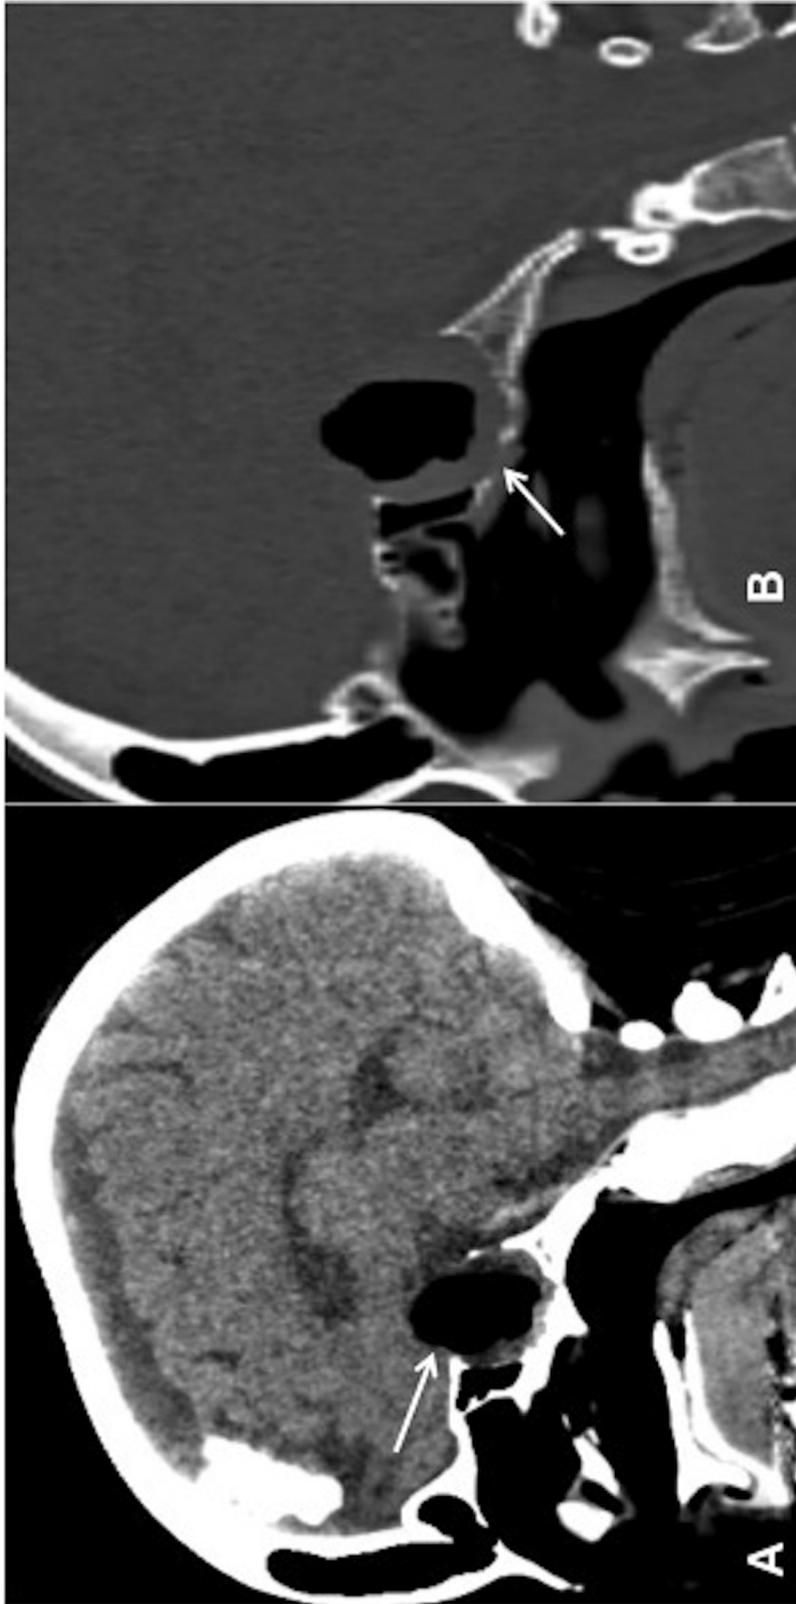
Midline sagittal non-contrast CT image of the head in soft tissue window (A) and slightly off-midline sagittal image in bone window (B) demonstrate marked expansion of the sella, and a large central collection of air/gas within the sella and suprasellar cistern causing compression on the optic pathways (A, arrow) and erosion of the sellar floor (B, arrow).
